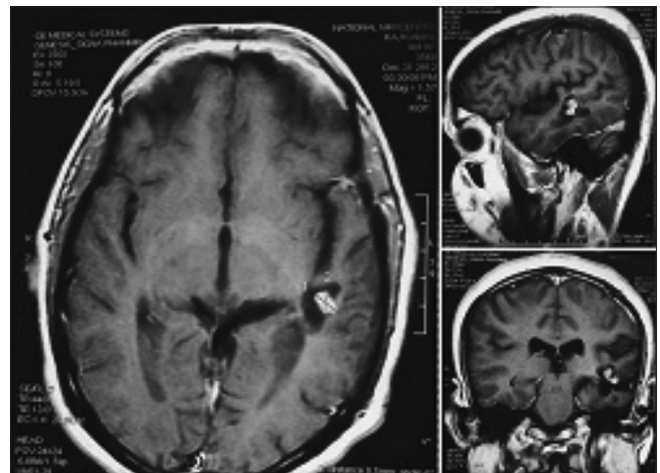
Postoperative magnetic resonance imaging scan
